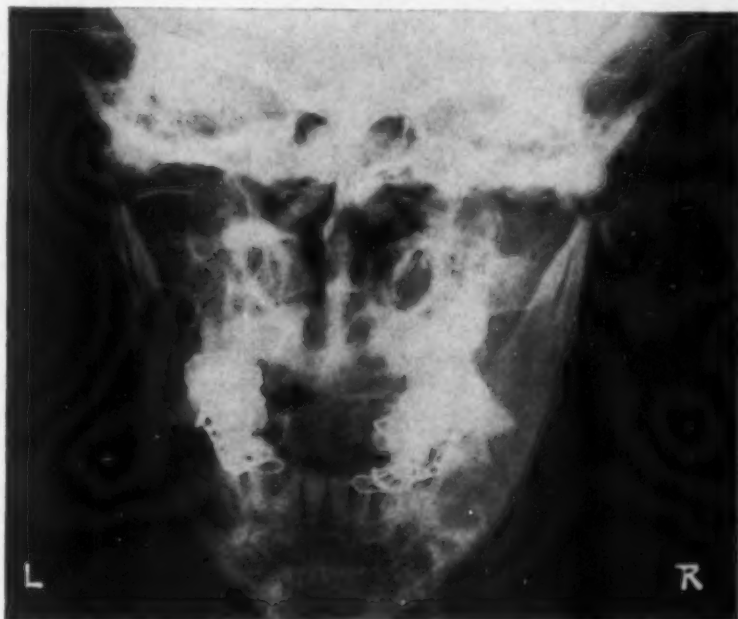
Anteroposterior x-ray showing fracture of both condyles. On the left there is a fracture dislocation with medial displacement; on the right the lateral displacement of the condyle caused synarthrosis.
